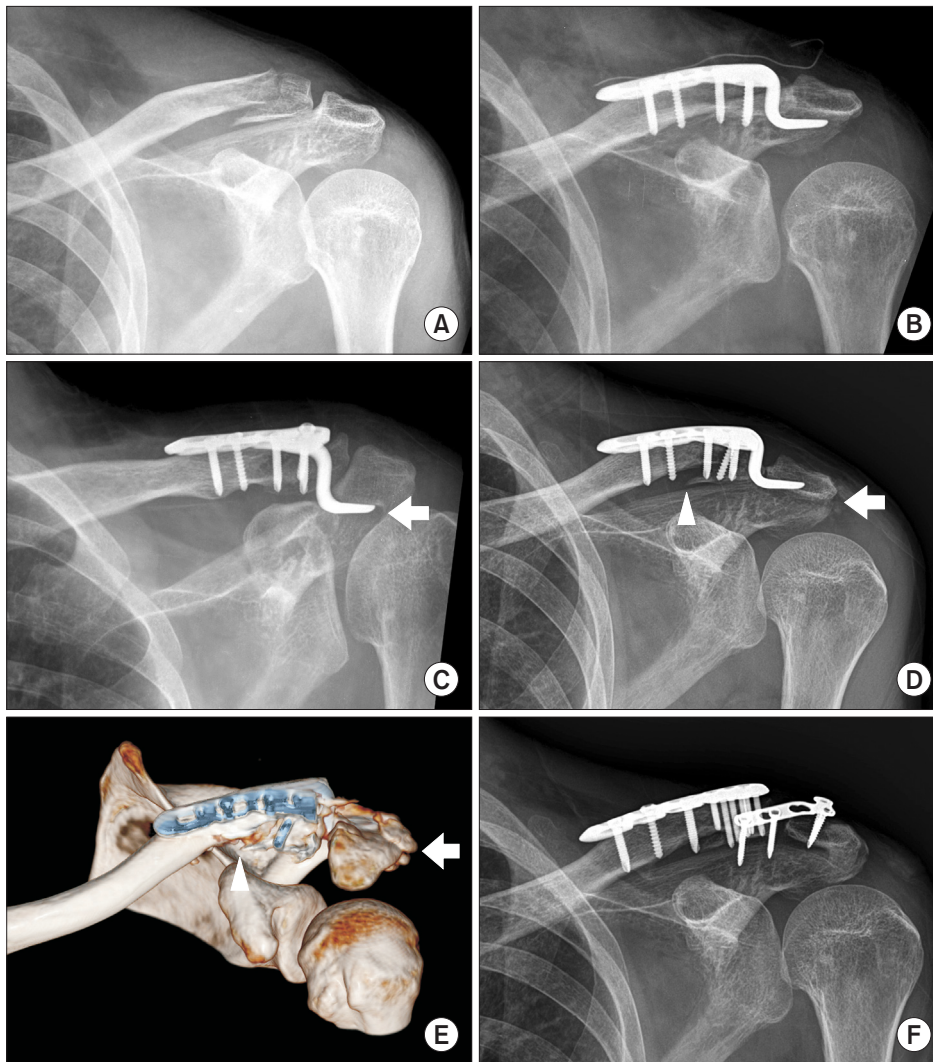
(A) The initial radiography showing Neer type IIB fracture of lateral end of clavicle. (B) Immediate postoperative radiograph showing acceptable reduction and internal fixation with locking compression plate clavicle hook plate. (C) At postoperative 2 weeks, radiography showing erosion (arrow) around the hook of the plate. (D) The follow-up radiography taken 6 weeks after fixation showing displacement of fracture site (arrowhead) and fracture of acromion (arrow). (E) At postoperative 7 weeks, 3-dimensional computed tomography showing fracture of the acromion (arrow) and displacement of fracture site (arrowhead). (F) Radiography obtained 8 months after initial surgery showing callus formation and partial union of the acromion and union of the clavicle.
